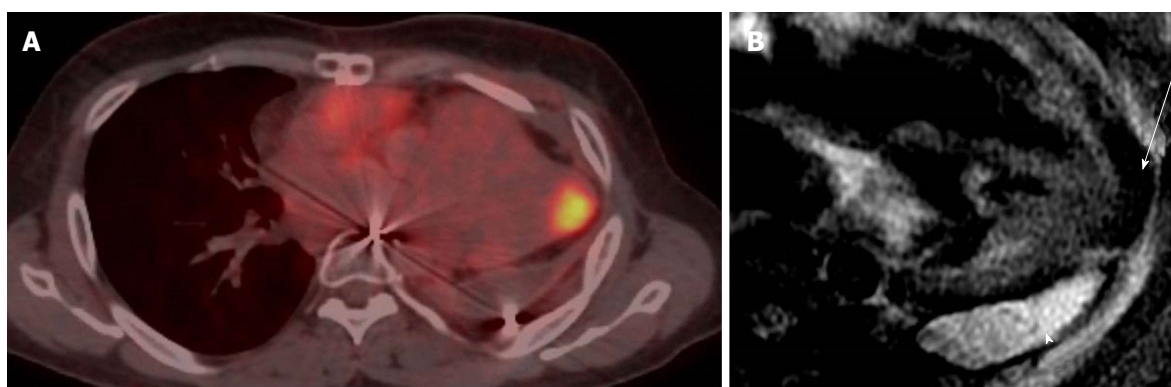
Localization and characterization of abnormal fluorodeoxyglucose activity in the heart. A: Axial PET-CT images in patient with history of invasive thymoma underwent surgical resection shows intense FDG focal uptake in the cardiac apex highly suspicious for cardiac metastases, review CT component of PET-CT shows area of and soft tissue; B: Four-chamber DE image with triple inversion recovery shows complete fat suppression of the apical activity in keeping with brown fat (arrow), with high signal fluid intensity consistent with post-operative lobulated fluid collection (arrowhead). PET: Positron emission tomography; CT: Computed tomography; FDG: Fluorodeoxyglucose.
